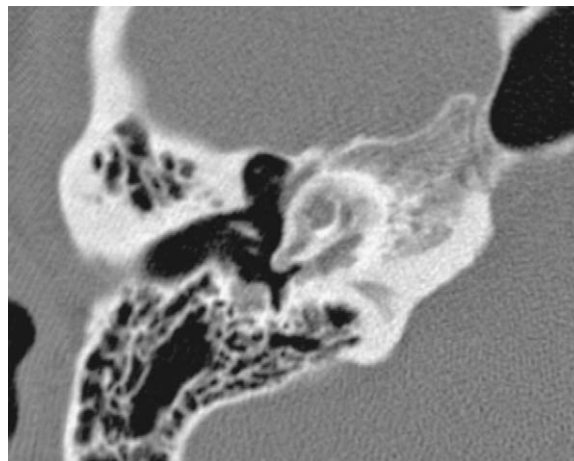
Transverse CT section demonstrates confluent pericochlear radiolucency in a patient with cochlear otospongiosis.
